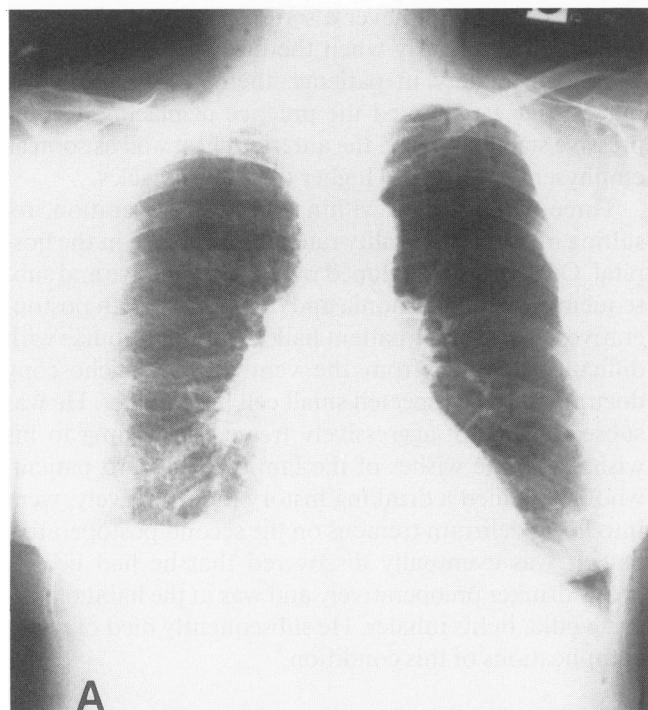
(A) This representative posterior–anterior chest x-ray was obtained 3 months after right-side reduction pneumonoplasty. It shows a right hemithorax that is considerably smaller than the left hemithorax. (B) The lateral film shows that the left hemidiaphragm remains flat, while the elevated right hemidiaphragm is now dome shaped.
